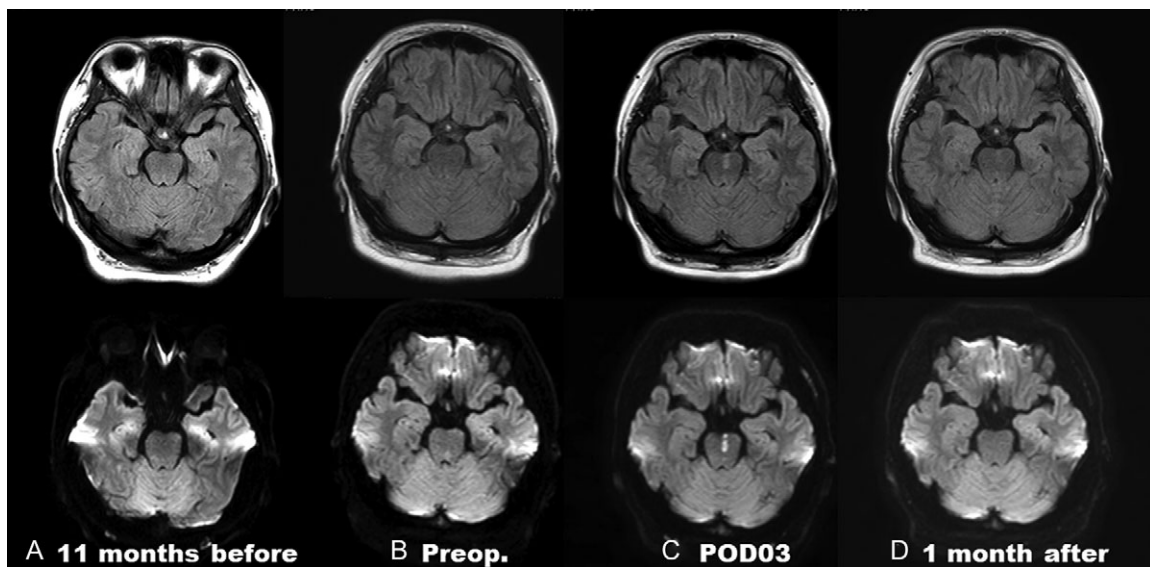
Serial magnetic resonance images (A-D) show emergence (B and C) and disappearance (C and D) of left medial pontine ischemic lesion. Upper: FLAIR, lower: DWI.
